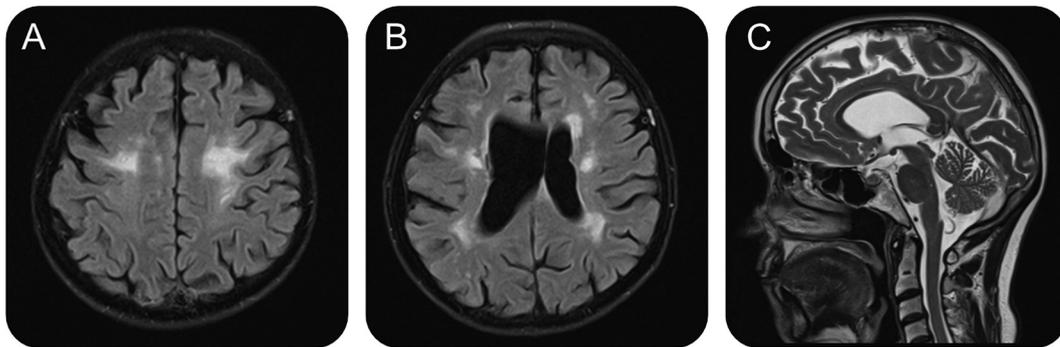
MRI features suggestive of HDLS. (A, B) FLAIR sequences demonstrating predominantly frontal patchy white matter lesions sparing U-fibers and involving the corticospinal tract. (C) Sagittal T2 sequence shows thinning of corpus callosum.
